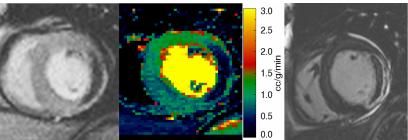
One midventricular timeframe of DCE-MRI series (left), corresponding MBF map (middle) and delayed gadolinium enhancement with an expansive no- reflow zone of the lateral wall (right).
